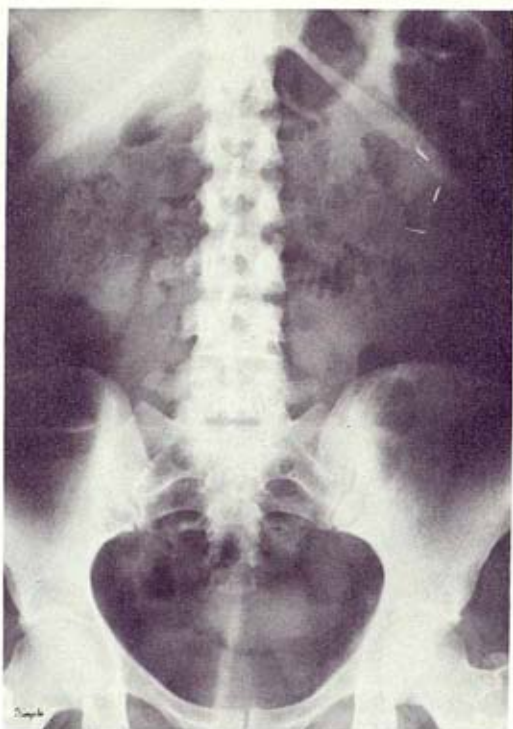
(Ob.I) Simple post-operative X-ray. Total removal of the calculi. Those of the right kidney were removed through an enlarged pyelotomy and the left kidney through enlarged pyelotomy and two complementary nephrotomies.
